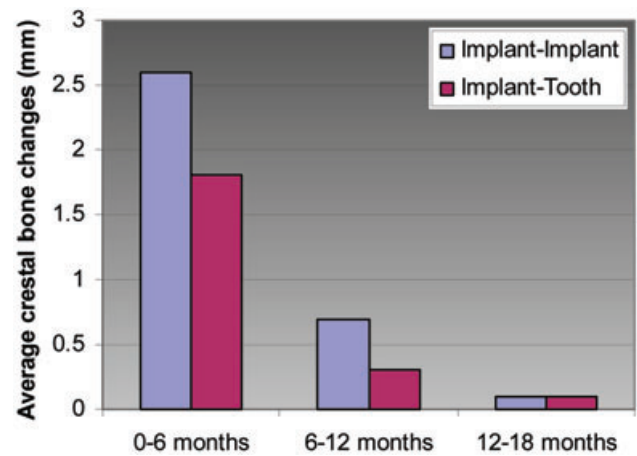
Average radiographic crestal bone change (mm) from placement to 18 months: implant-implant versus implant-tooth sites.
